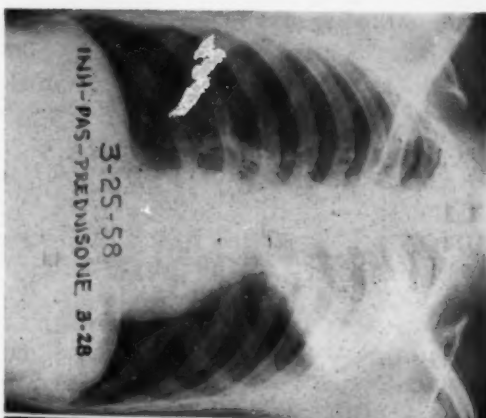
Case 1—E.W.—Admission chest x-ray film.
